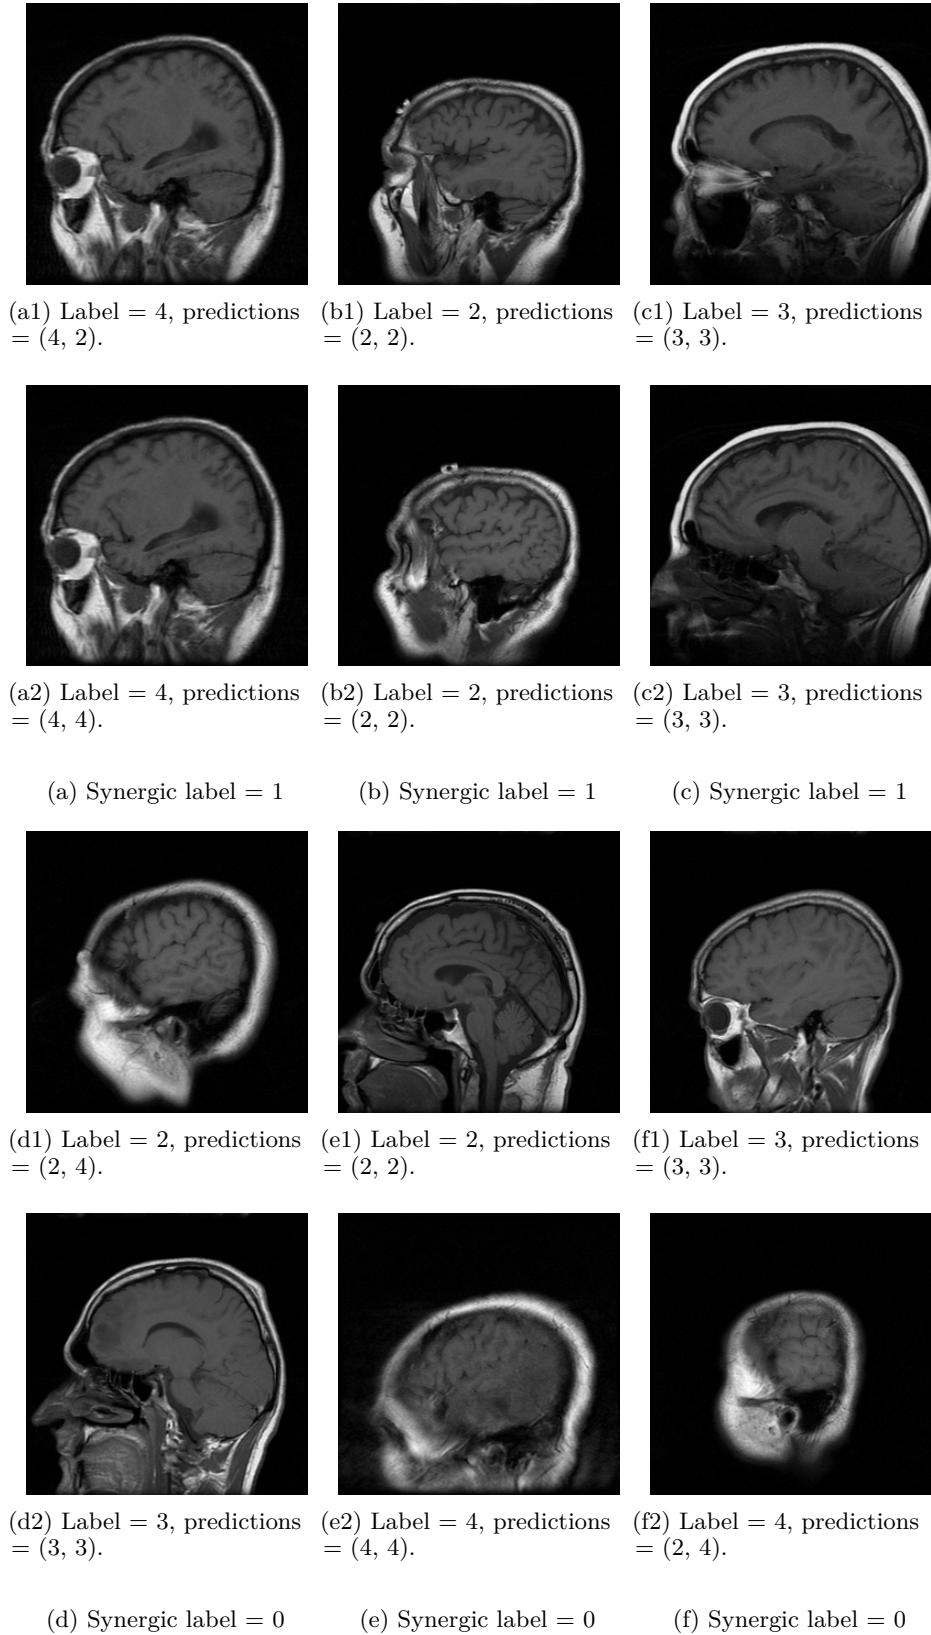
Input MRI slices, target labels, and predictions by the 2 DCNNs.
